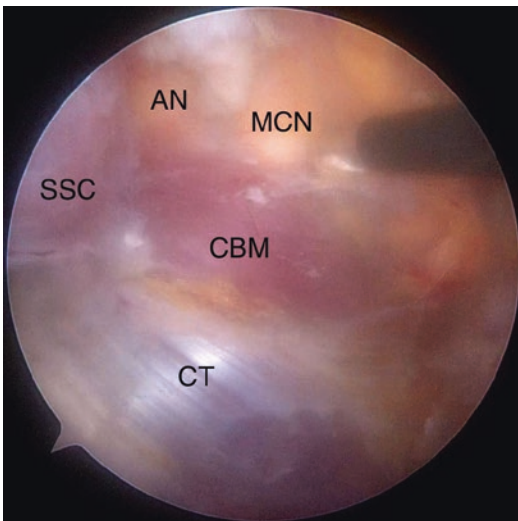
Arthroscopic images demonstrating anatomical changes with motion. *MCN* musculocutaneous nerve; *CBM* coracobrachialis muscle; *CT* conjoint tendon; *AN* axillary nerve; *SSN* suprascapular nerve; *PMR* pectoralis minor fascia remnants
